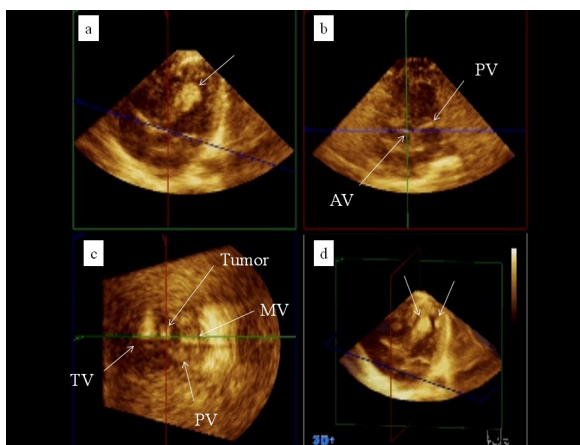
Real-time three-dimensional echocardiographic findings of cardiac tumors during neonatal period.
